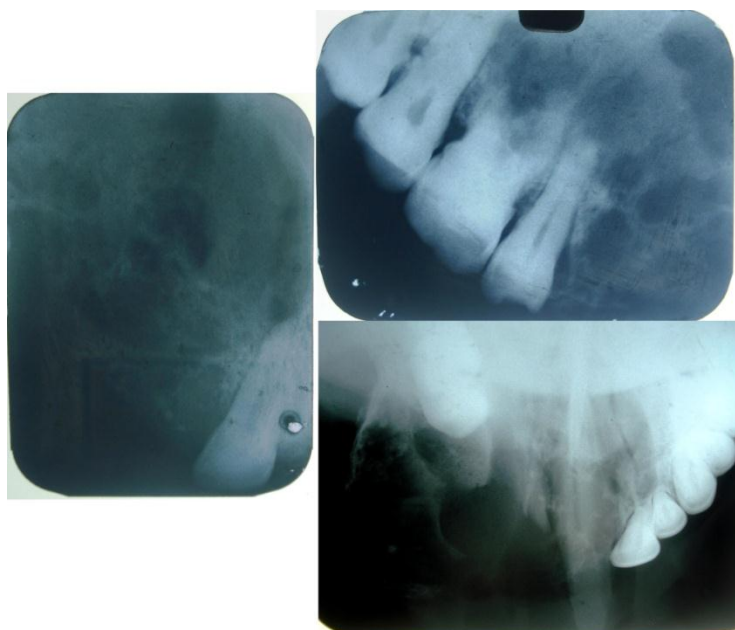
Intraoral periapical radiograph and anterior maxillary occlusal radiograph showing multilocular radiolucency extending from the midline to mesial aspect of 25.
